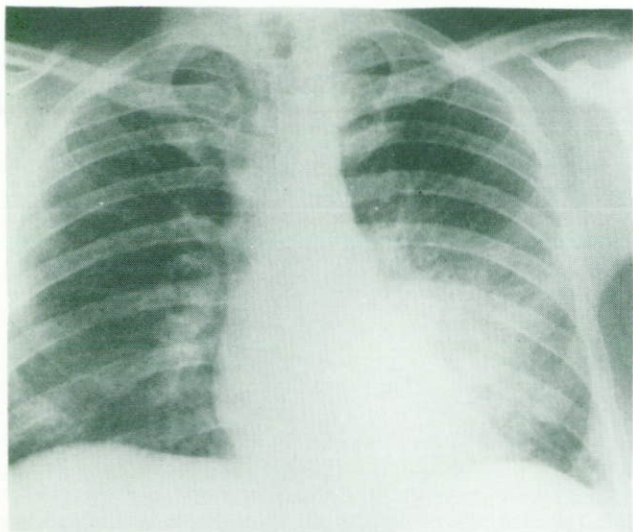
(A) The chest radiograph of a 35-year-old man with left lower lobe pneumonia. (B) The lateral film suggested a loculated empyema which was also suspected clinically because of a swinging fever. (C) Ultra-sound did not detect fluid but confirms consolidated lung, also confirmed by tomography.
